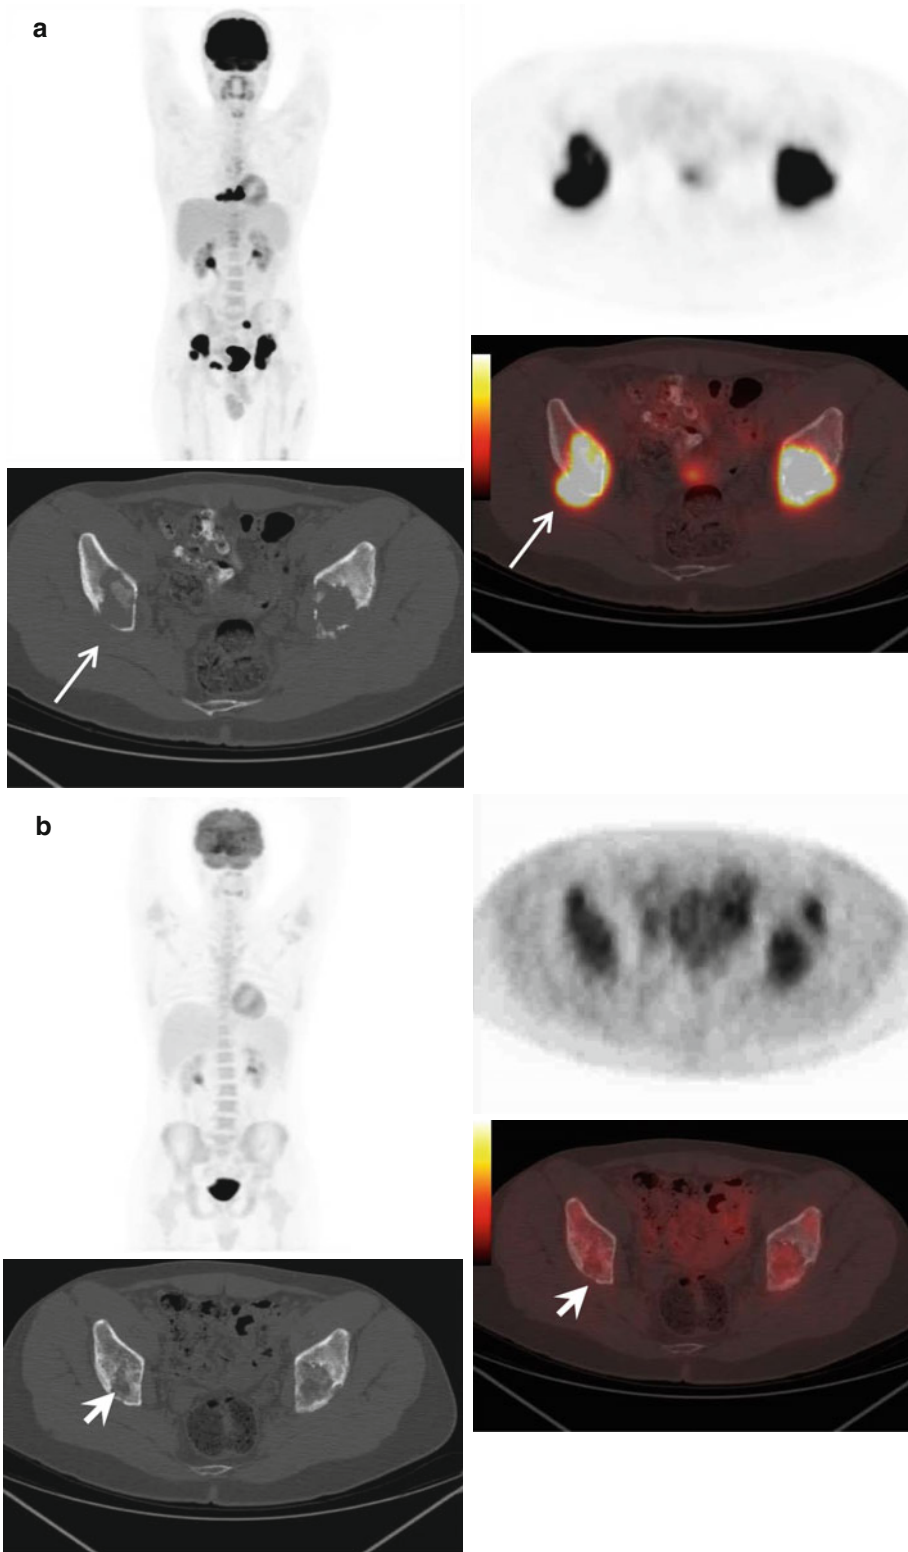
A 50-year-old patient with diagnosis of lymphoma. (a) Pretherapy FDG-PET-CT images show lytic bone involvement with soft tissue component (*white arrows*).
